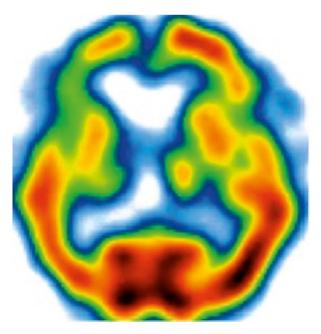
Corticobasal degeneration ([99mTc]-HMPAO SPECT) with asymmetric perfusion of basal ganglia and cerebral cortical hypoperfusion, mainly expressed in frontotemporal area, contralateral to clinically more affected side
